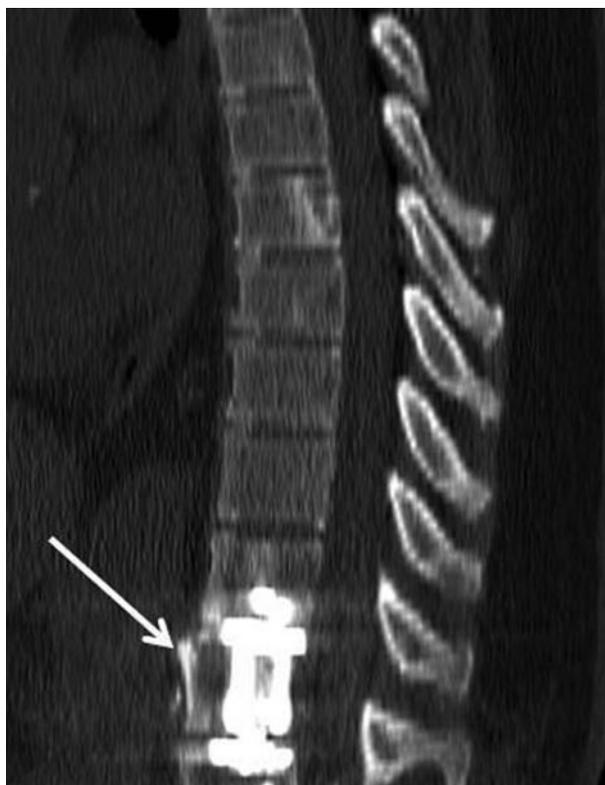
Postoperative magnetic resonance image demonstrating T11 to L1 fusion with expandable titanium cage and T11 to L1 plating with anterolateral plate (arrow).
